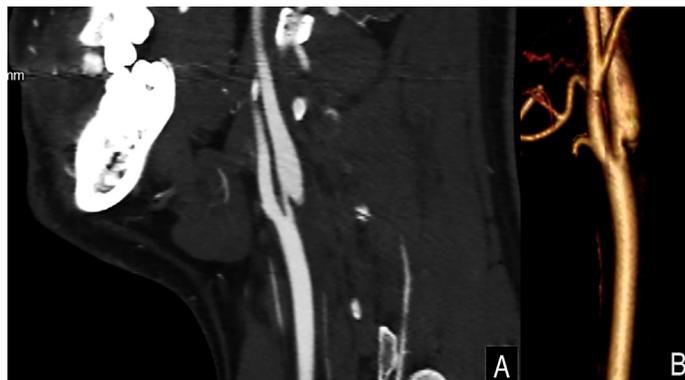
A) Supra-aortic CT angiography reconstruction, showing significant stenosis of the LICA B) 3D Supra-aortic CT angiography reconstruction of the LICA
